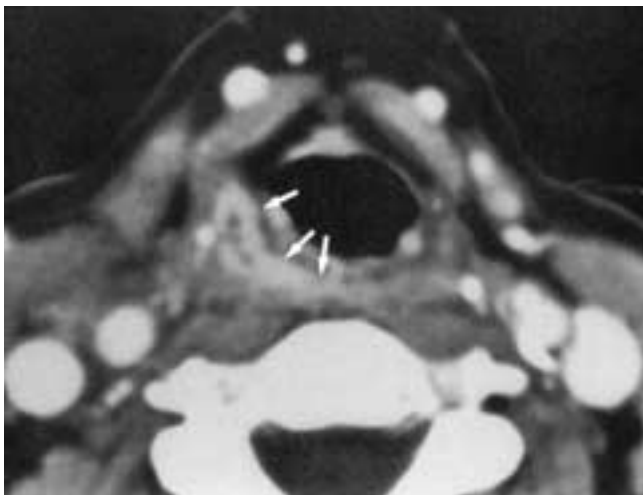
Contrast-enhanced CT scan performed in a patient with a low volume (<6 cc) piriform sinus carcinoma arising from the right piriform sinus (*arrows*). The tumor extends to the midline, thereby precluding treatment with wide local excision or partial pharyngectomy. (From Mukherji SK, Pillsbury H, Castillo M. Imaging squamous cell carcinomas of the upper aerodigestive tract: what the clinicians need to know. *Radiology* 1997;205:629-646.)
